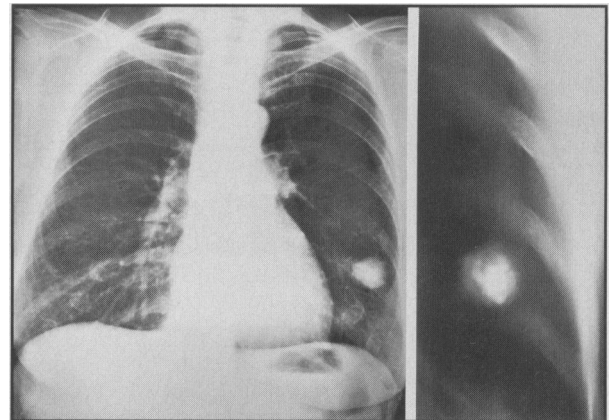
Chest radiograph (left) of a 45-year-old male (Case 7) showing a round 3.5-cm solitary nodule in the superior segment of the right lower lobe with popcorn calcification. A tomograph (right) shows the detail of the popcorn calcification of the nodule.
